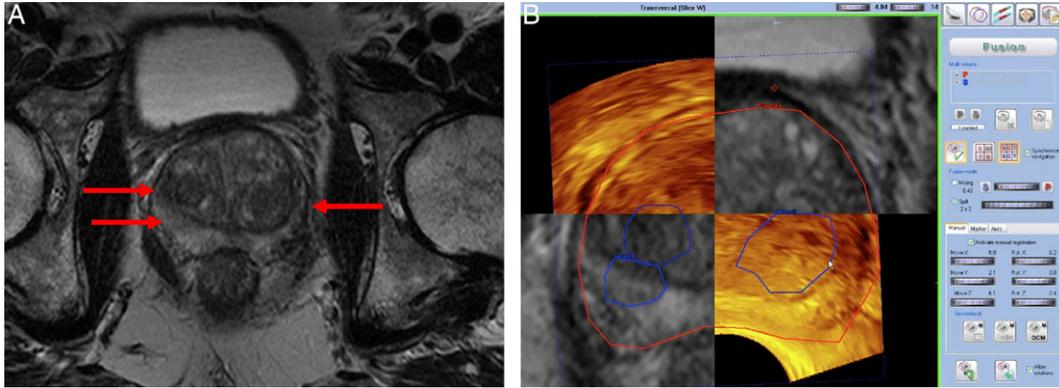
A, multiparametric MRI was done to detect suspicious lesions. Regions of interest were marked on high spatial resolution T2w TSE sequences in transverse plane. In this patient note 1 highly suspicious area in right peripheral zone and 2 questionable lesions in right and left transition zones, respectively. MRI and US data 3D registration was achieved by custom software under simultaneous visualization of axial, coronal and sagittal planes. B, axial screenshot shows MRI (gray areas) and TRUS (orange areas) data.
